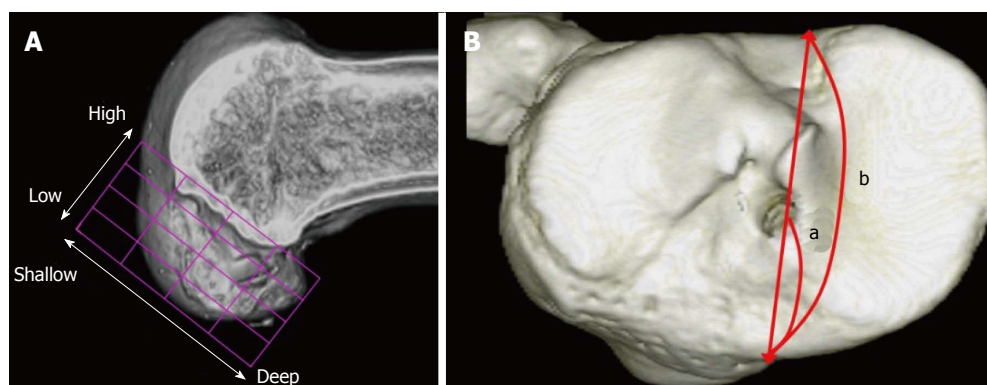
Evaluation of tunnel positions in femur and tibia. A: 3D CT-based model of a femoral bone tunnel after an ACL reconstruction. Tunnel position was assessed according to the quadrant method^[46]. Depth = (distance from the posterior edge to tunnel center along Blumensaat's line/total length of the lateral condyle) \times 100%. Height = (distance from Blumensaat's line to tunnel center/total height of the intercondylar roof) \times 100%; B: For tibial side, Staubli's technique was used^[47]. Anterior-posterior position = (a/b) \times 100%. a: Distance from anterior edge to tunnel center; b: Anteroposterior length of the tibia plateau. ACL: Anterior cruciate ligament.
